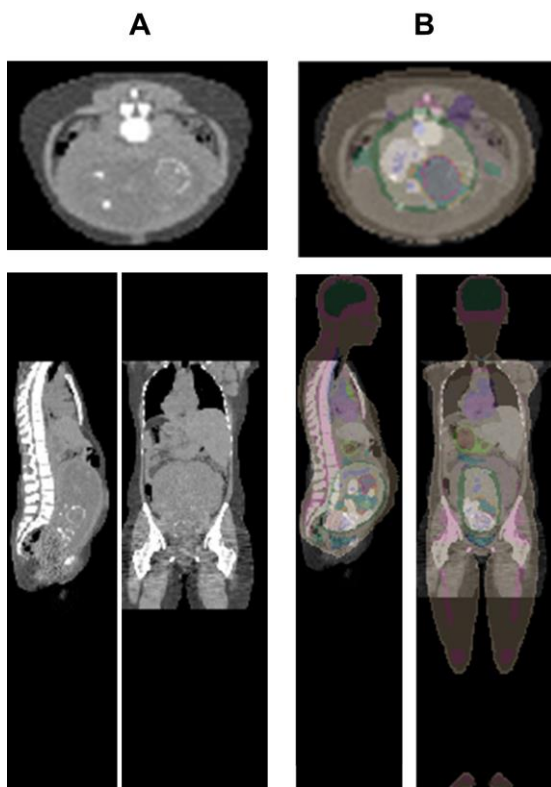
Representative slices showing transverse (top), sagittal (bottom and left) and coronal (bottom and right) views of two examples of the (A) original CT images of patient and (B) registered computational model with patient image.
